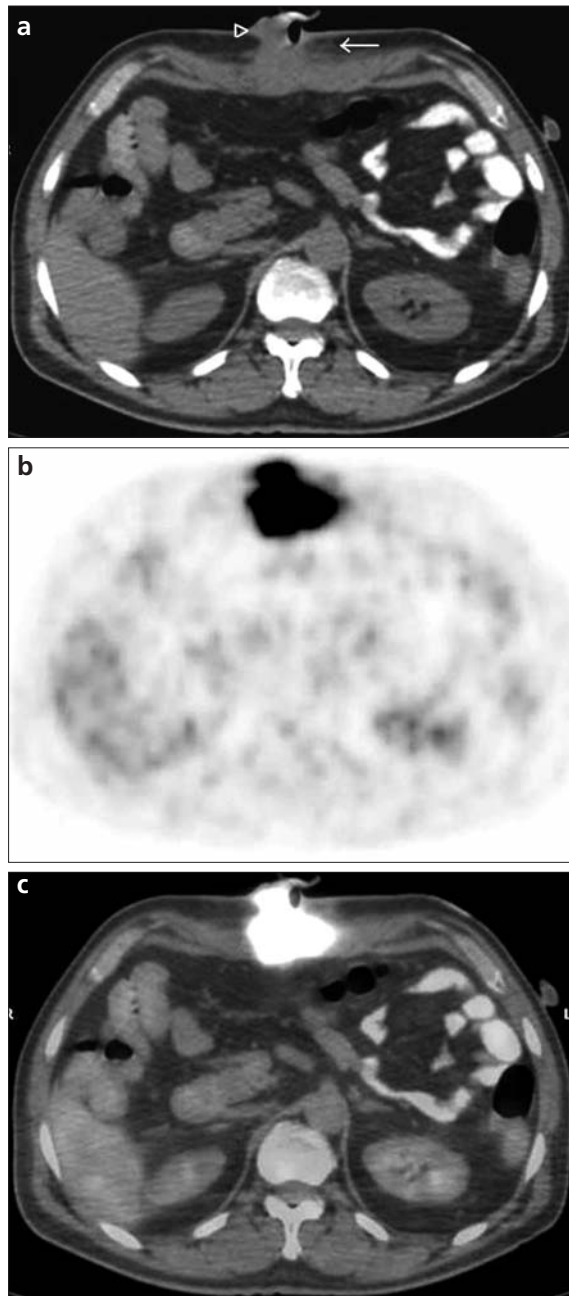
a-c. 52-year-old man operated for squamous cell carcinoma of the buccal mucosa who presented with symptoms of swelling and pain at the percutaneous endoscopic gastrostomy (PEG) site. Biopsy revealed an abscess. Non-enhanced CT image (a) shows a soft tissue mass at the PEG site (arrow head) associated with fat stranding in the abdominal wall (arrow). PET image (b) shows intense FDG uptake at the PEG site. Fusion PET-CT image (c).
